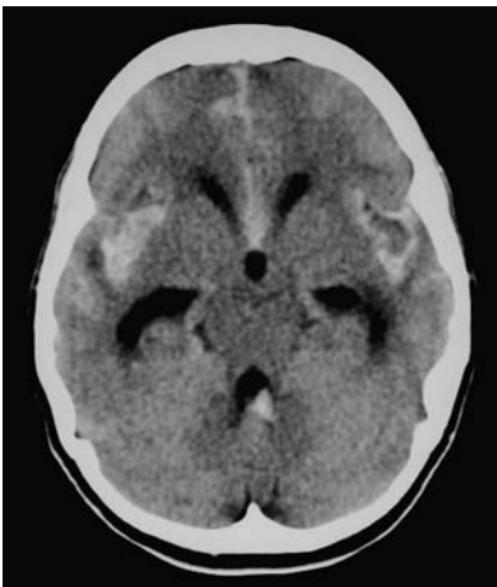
Subarachnoid haemorrhage (SAH); anterior communicating artery aneurysm. (a) Non-enhanced CT; (b) digital subtraction angiography. Acute subarachnoid haemorrhage in the suprachiasmatic cistern and fourth ventricle with a focal haematoma in the inferior aspect of the anterior interhemispheric fissure at the site of the anterior communicating artery (ACom). Note the surrounding bilateral inferior frontal parenchymal low attenuation representing early ischaemia. Catheter angiography confirmed the presence of an irregular small aneurysm (black arrow) arising from the junction of the A1 and A2 segments of the left anterior cerebral artery (open black arrow). There is marked vasospasm and slower flow in the proximal left anterior cerebral artery (black arrowheads) with reduced opacification of the distal vessels in the ACA territory.
